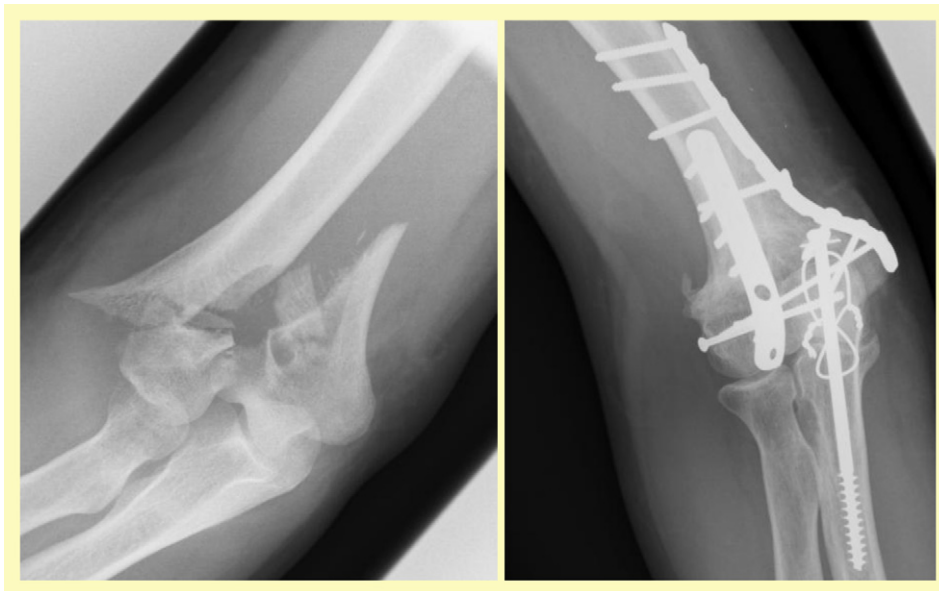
Radiograph of a comminuted intra-articular distal humerus fracture. Post-operative radiograph demonstrates 90° configuration of humeral plates. The reduction of the fracture was performed through an olecranon osteotomy which was then stabilized with an intramedullary screw and tension band.
